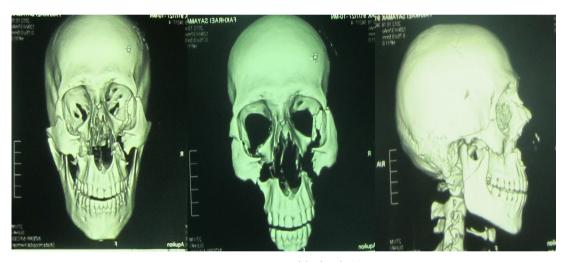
Pre-operation of the facial CT scans
